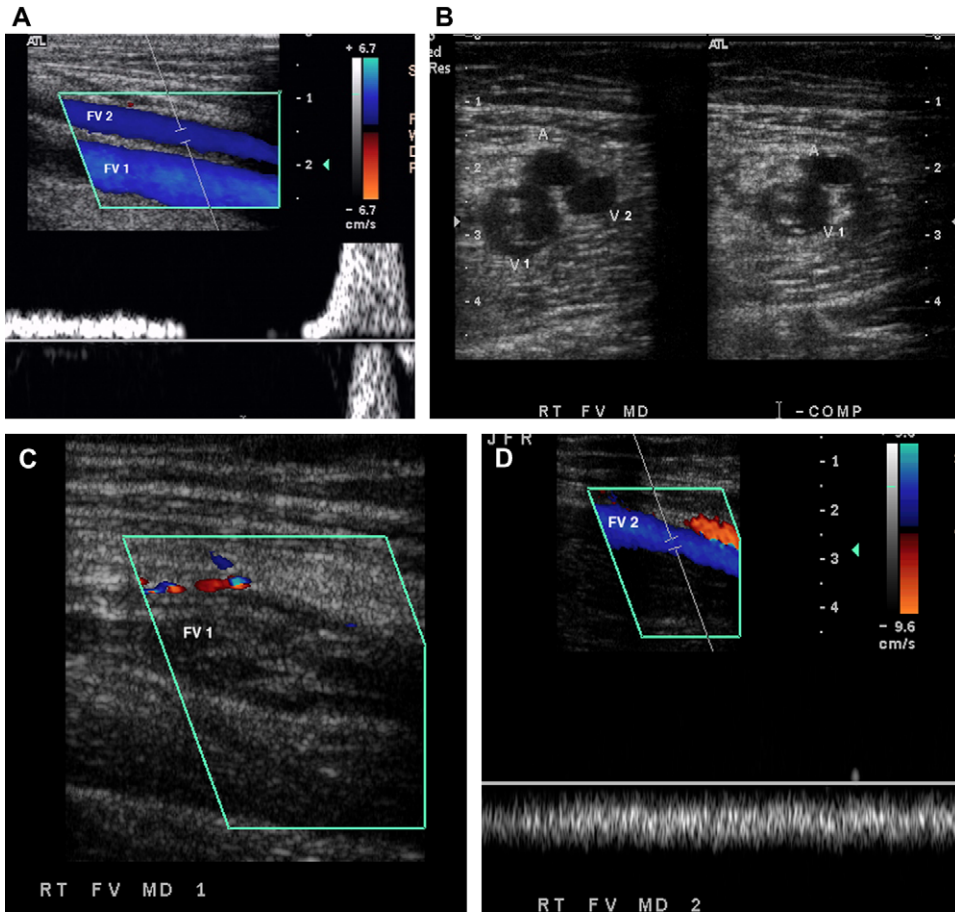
(A) Sagittal color Doppler US of duplicated femoral vein (FV). (B) Transverse US of duplicated femoral vein demonstrating noncompressibility of thrombosed limb (V1). (C) Sagittal color Doppler US limb of a duplicated femoral vein (FV1). (D) Sagittal color Doppler US of normal flow in duplicated femoral vein (FV2).
